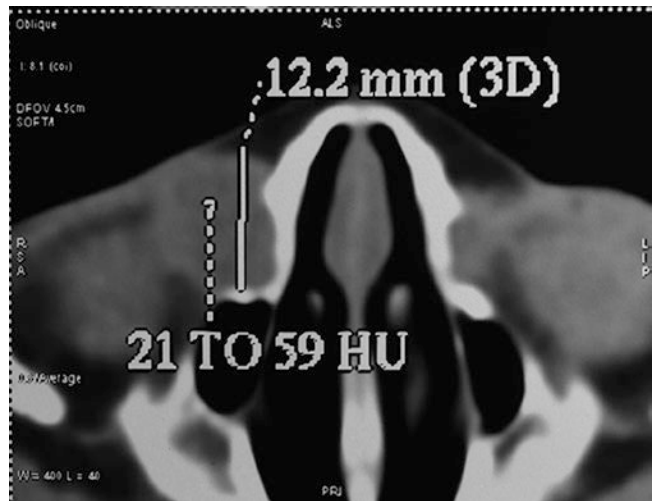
CT scan, axial section of the patient in Fig. 2.14. Note the mass lesion arising from the lacrimal fossa and the huge lacrimal sac
